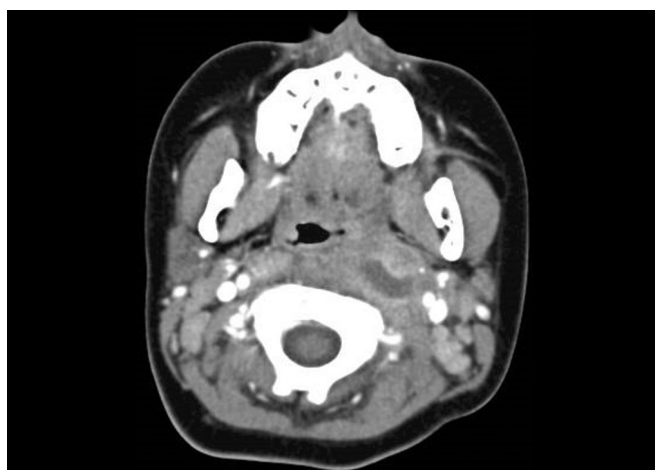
Retropharyngeal abscess in a 7-year-old boy presenting with fever and difficulty breathing and swallowing. An axial contrast enhanced CT shows a rim enhancing central low attenuation lesion in the left retropharynx. The lesion lies in the expected local of the left node of Rouviere but the enhancing borders appear irregular and extend slightly outside the borders of the lymph node—findings suggest suppuration.
